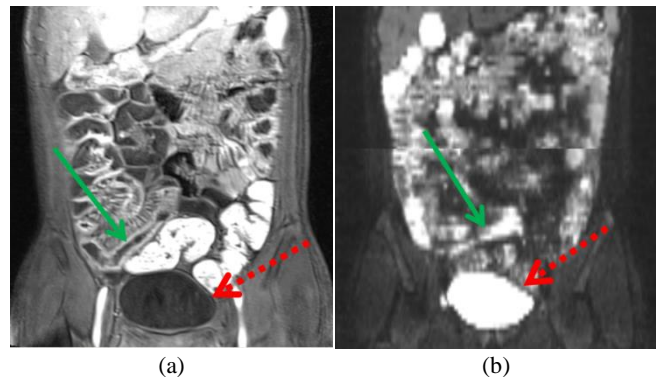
(a) The structural T1w, and (b) the DWI image ($b=100 \text{ s/mm}^2$) from the coronal view show the bladder (identified by the red dashed arrows) and the enhanced bowel wall (identified by the green arrows) which causes contrast inhomogeneity.
